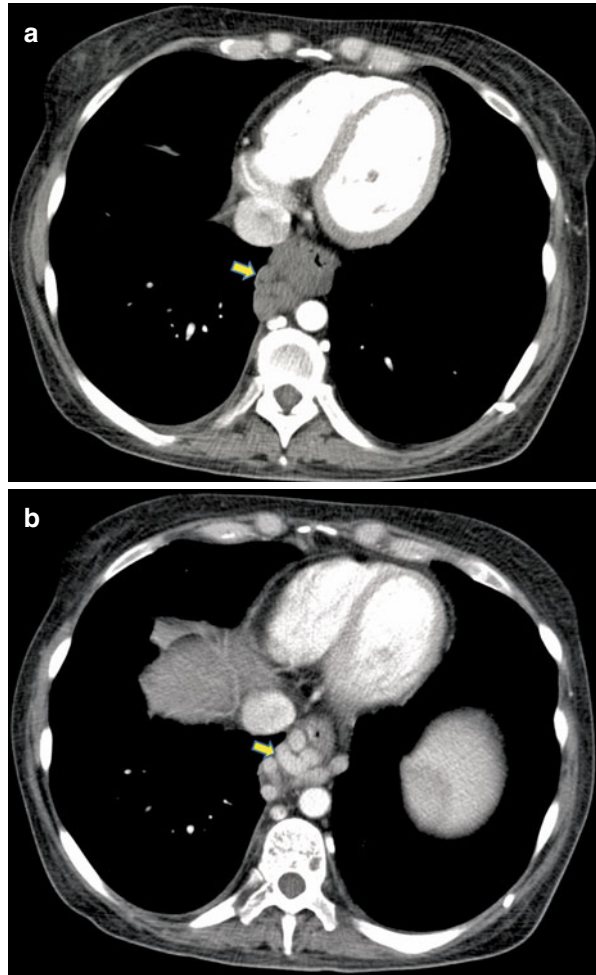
(a) Axial contrast-enhanced early arterial phase CT shows splenic hilar collateral vessels (*arrow*) that may appear as nodal mass. Delayed arterial phase (b) shows opacification of the vessel (*arrow*) and confident diagnosis of non-nodal etiology
